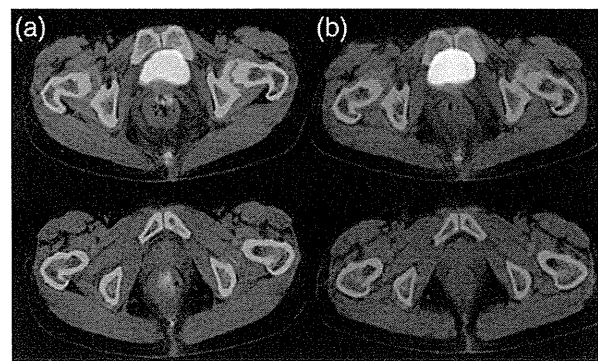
F-MISO PET/CT (a) before RT, and (b) during RT (18 Gy/10 fractions), for a patient with anal canal squamous cell carcinoma (case 7: T2N0M0). In this patient, F-MISO accumulation in the primary tumor (SUVmax; 2.44) decreased to 2.08 in the second F-MISO study at 18 Gy/10 fractions.
